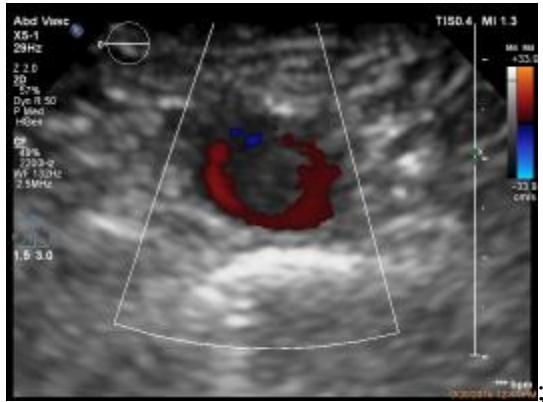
2D ultrasound showing a slight thickening of the aortic wall and an intima with an irregular contour
